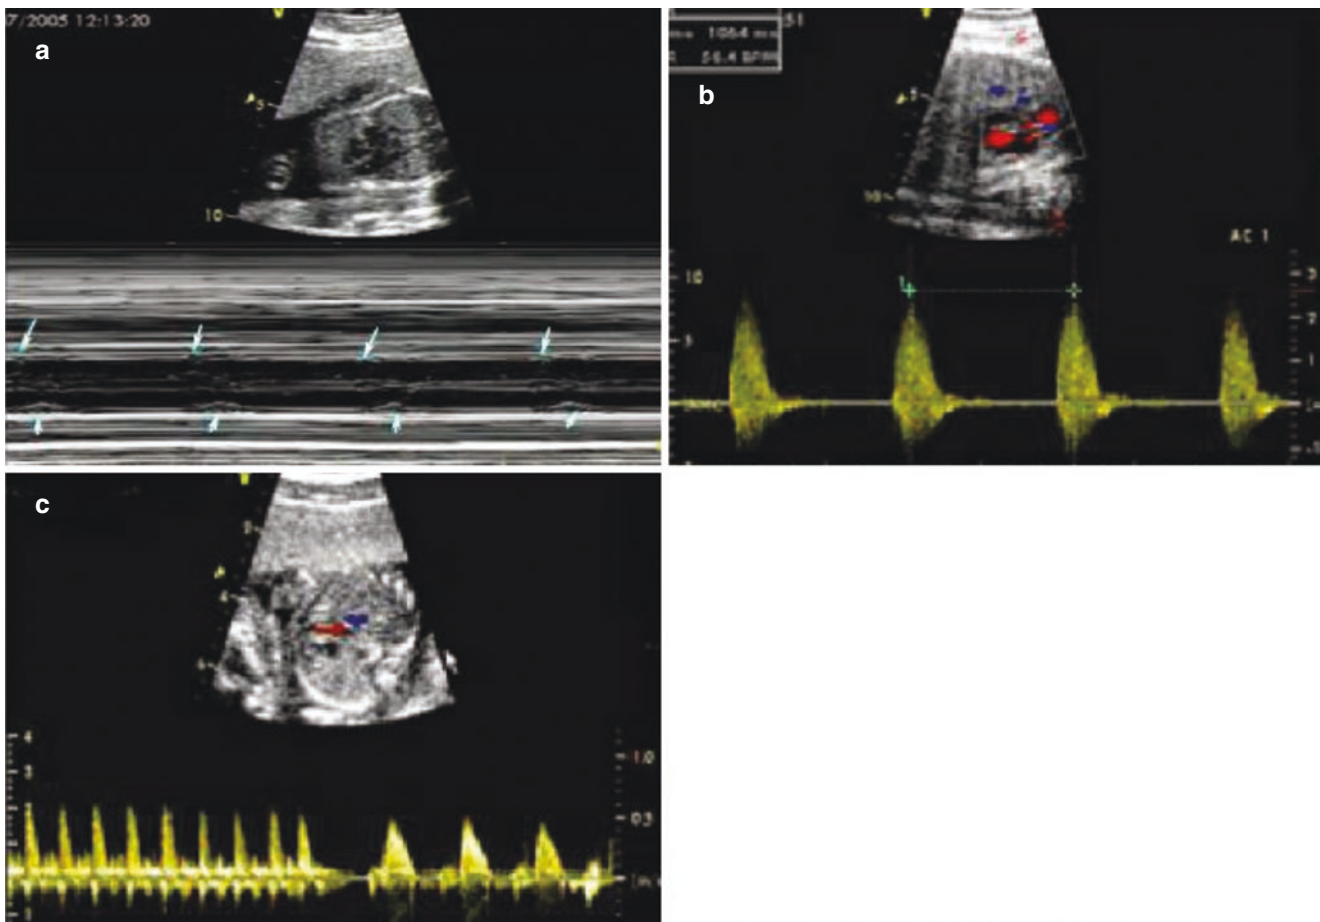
Fetal sinus bradycardia. (a) M-mode ultrasound shows fetal bradycardia. (b) Spectrum Doppler ultrasound shows fetal bradycardia. (c) Spectrum Doppler ultrasound shows fetal tachycardia changing into bradycardia, with alternating fast and slow heart rate
